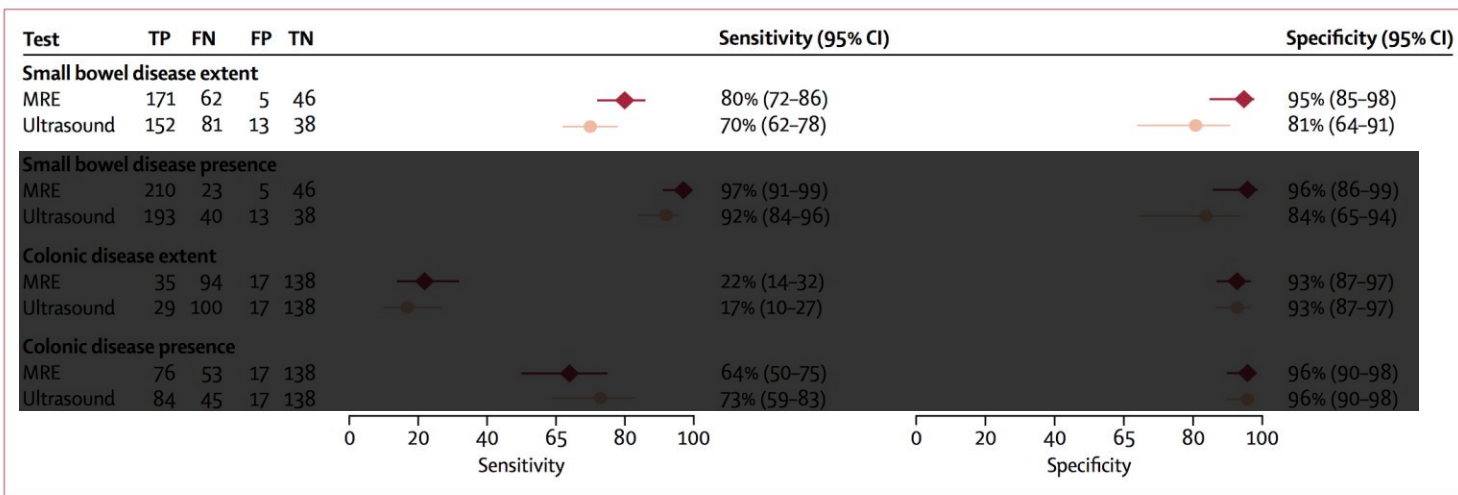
Sensitivity and specificity of MRE and ultrasound for the extent and presence of small bowel and colonic disease against the consensus reference standard
